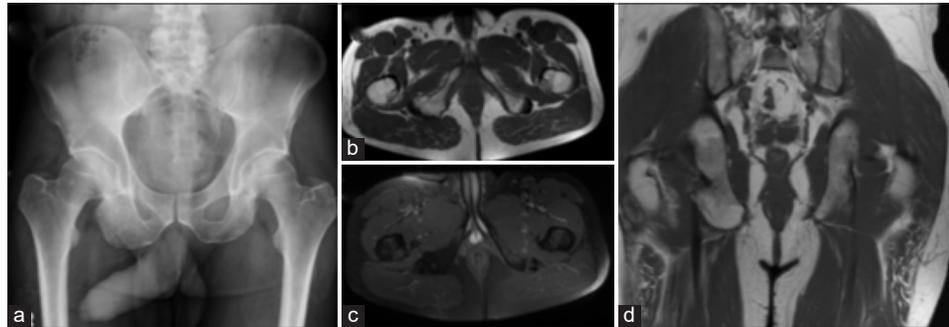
Chronic avulsion fracture of the ischium. Radiograph (a), axial T1 (b), short-tau inversion recovery (c), and coronal T1 (d) demonstrating chronic healed avulsion fracture of the right ischium.
